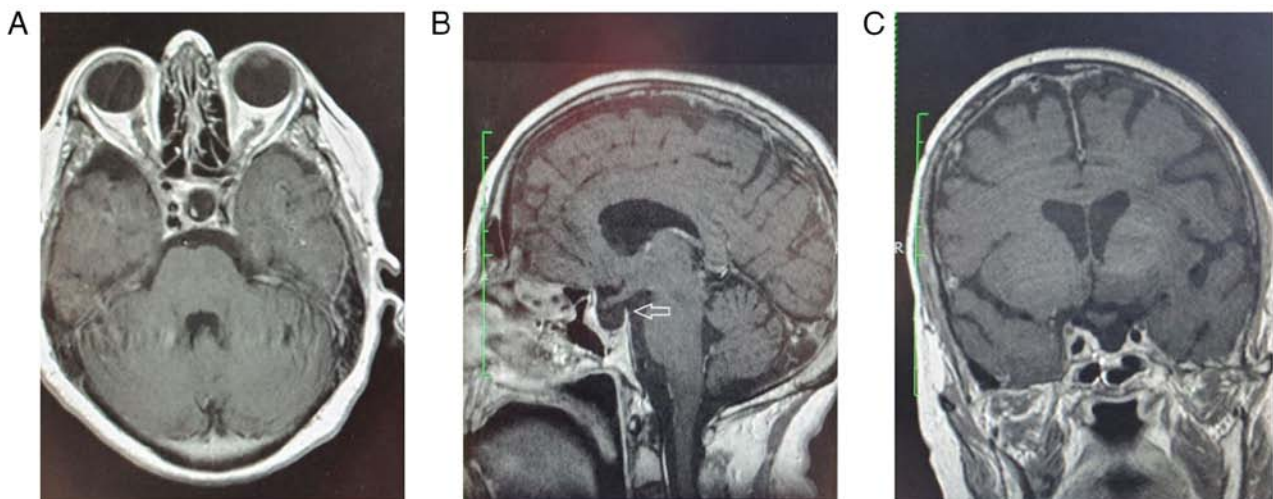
(A-C) Post-operative contrast enhanced T1 MRI scan of patient 6. No tumor is depicted, while the sella is empty (arrow).
